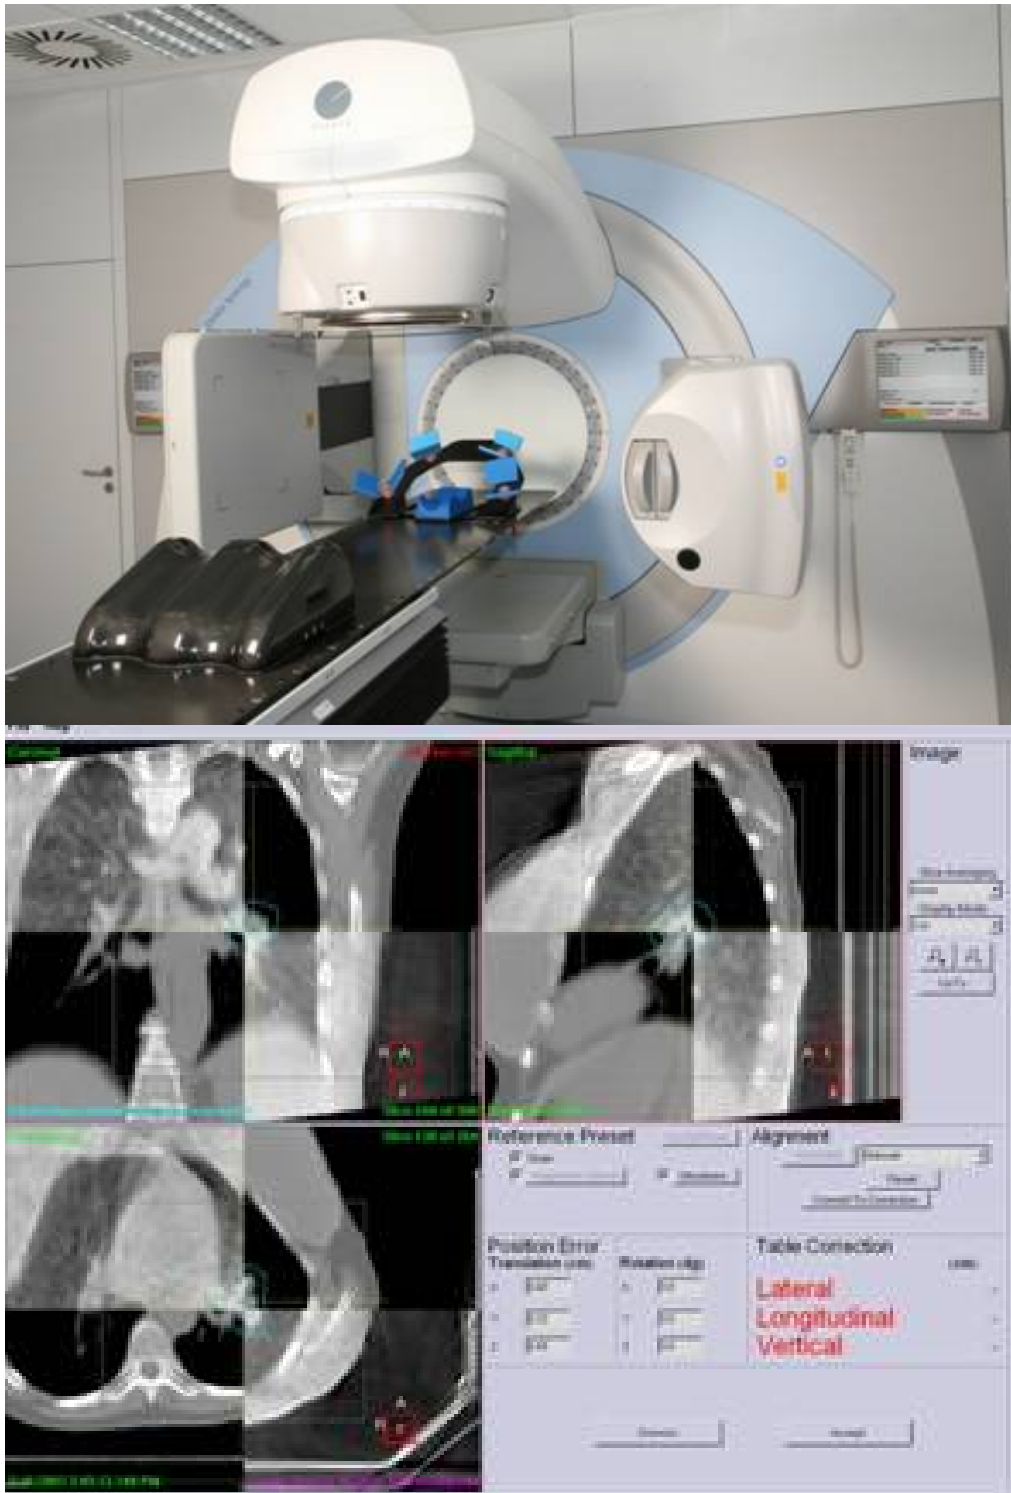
Elekta x-ray volume image (XVI) system with imaging registration software.
